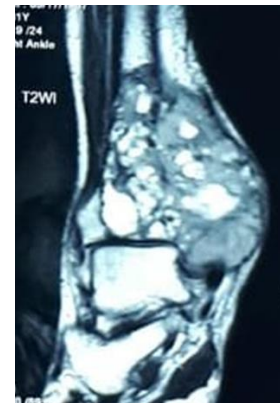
Magnetic Resonance Imaging showed distal tibia mass with thinning and destruction of the cortex, with intralesional characteristics suggestive for giant cell tumor
